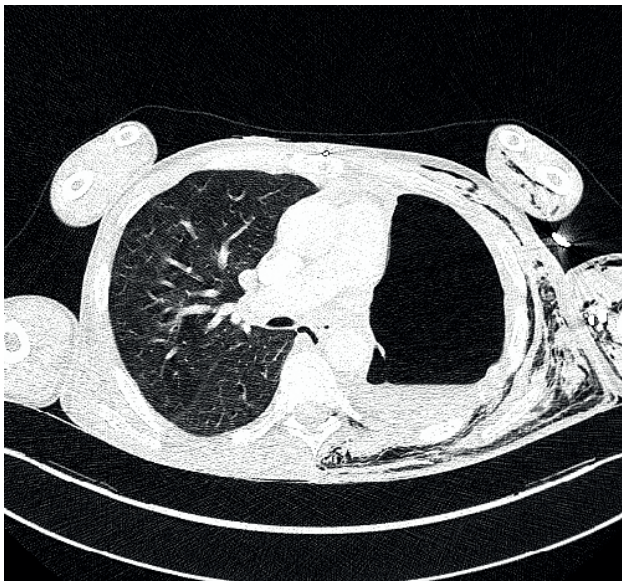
continued Presentation of bronchopleural fistula post pneumonectomy. Computed tomography axial images demonstrating:
